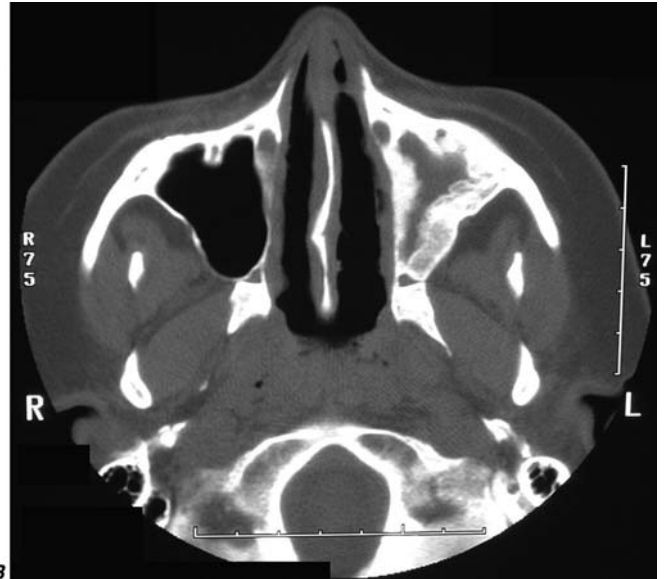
FIGURE e28-6 Computed tomography of the sinuses in two patients with Wegener's granulomatosis. (A) Mucosal thickening of the bilateral maxillary sinuses and a perforation of the nasal septum.
